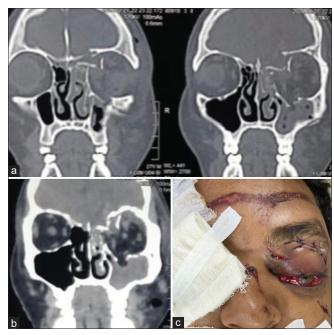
(a) Preoperative computed tomography coronal sections bone window showing the complex anterior cranial fossa fracture with floating lateral lamella of cribriform plate. (b) Preoperative computed tomography coronal section soft-tissue window with fracture fragment impinging on the superior rectus muscle. (c) Preoperative picture of the patient showing left eyeball displaced downward and laterally with conjunctival chemosis. Also note the edema of upper eyelid with linear sutured laceration through which the transorbital neuroendoscopic surgery approach was undertaken
